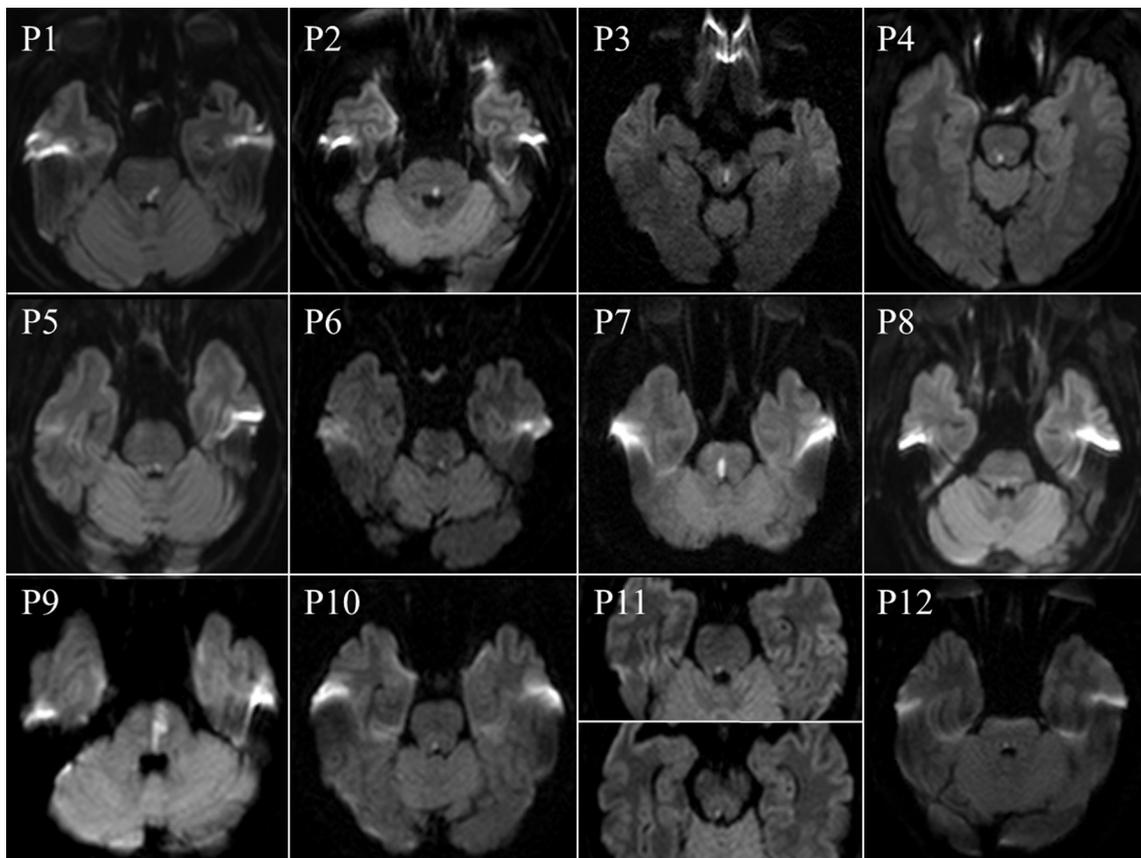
MRIs of patients. All the patients show a discrete infarction involving the brainstem, the pons in 10, the midbrain in 1 (patient 3), and the pons and midbrain in another (patient 11). The number in each MRI indicates the patient number in Table 1.
